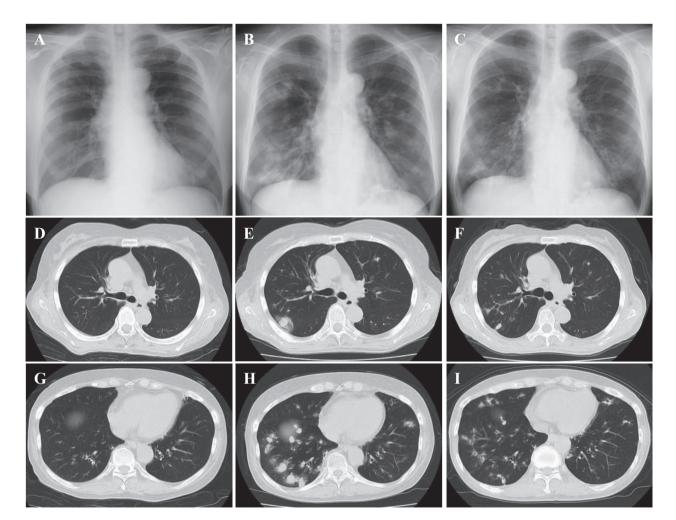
Clinical course of Chest X-ray and computed tomography. A chest radiograph (A) and chest CT scans (D and G) obtained on admission showed normal findings. Images obtained on day 21 of admission demonstrated multiple bilateral nodules with the halo sign (R>L) (B, E and H). Six months after admission, these findings improved with combination therapy for *Mycobacterium avium* complex infection (C, F and I).
